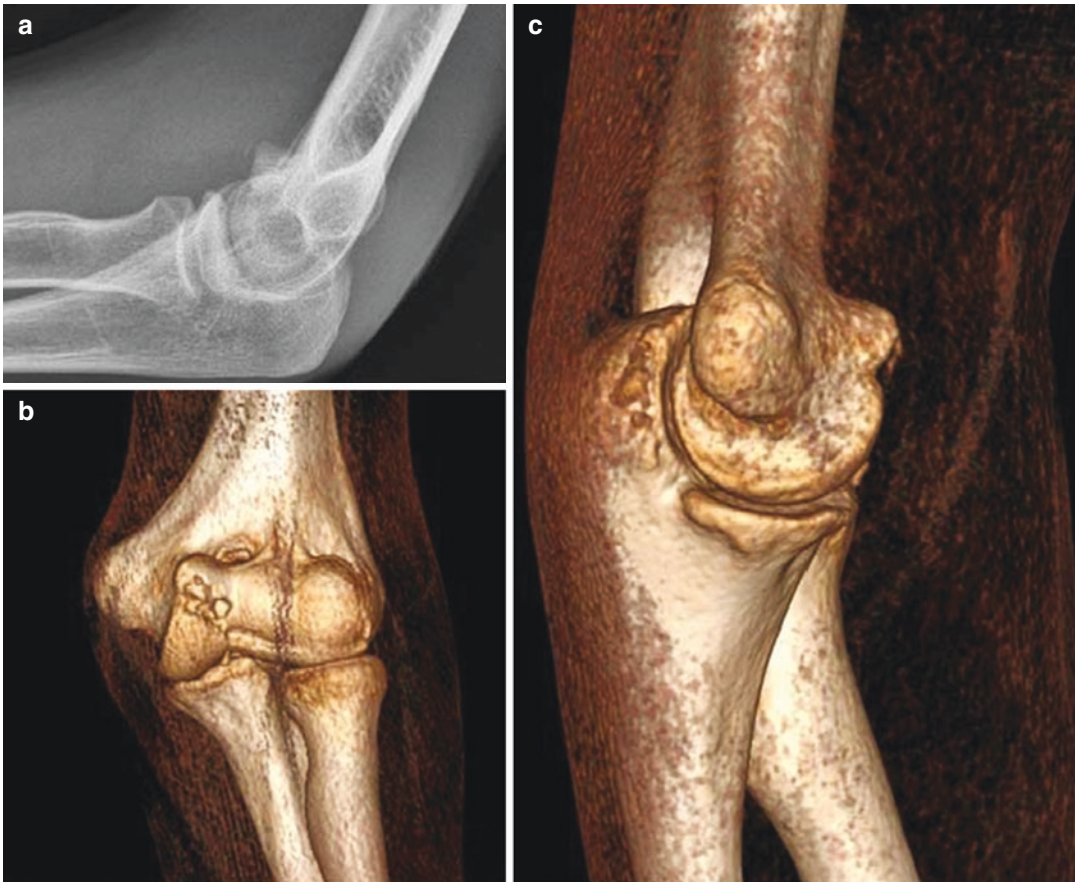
A 28-year-old patient with sequelae of coronal shear fracture of coronoid and trochlea. (a) Lateral radiography of semi-extended elbow shows a bony prominence at the anterior part of the distal humerus which causes a bony blockage of elbow flexion. (b) Anteroposterior view
